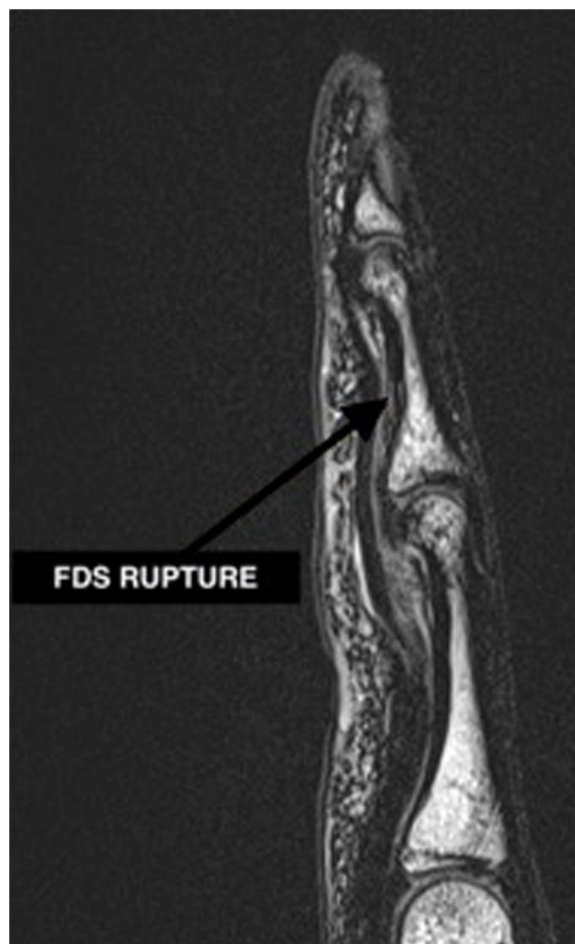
MRI of the middle finger of the left hand. The arrow indicates the site of the FDS rupture.
